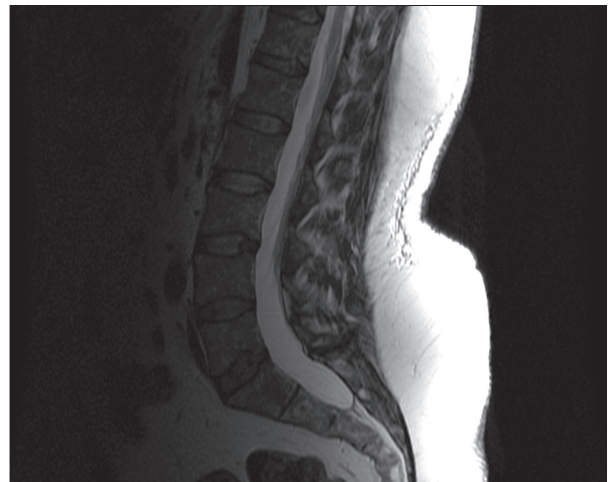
T2-weighted magnetic resonance scan obtained in sagittal plane in patient diagnosed with the RAEB subtype of myelodysplastic syndrome.
